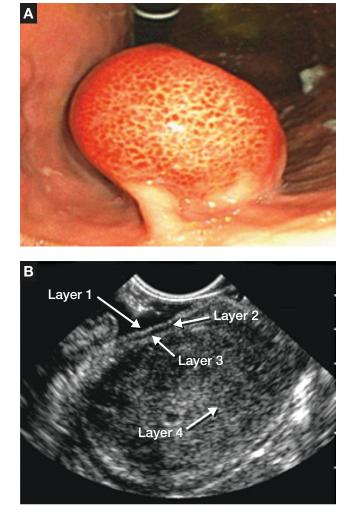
Pedunculated Gastric Gastrointestinal Stromal Tumor (GIST). A, Endoscopic image. B, Endoscopic ultrasonographic image. Endoscopic ultrasonography can demonstrate 5 wall layers, but only 4 layers are seen in this image. Layer 1 is hyperechoic (white) and is the superficial mucosal interface. Layer 2 is hypoechoic (black) and is deep mucosa. Layer 3 is hyperechoic and represents the submucosa. Layer 4 is the muscularis propria; it is hypoechoic (black) and is the layer of origin of most GISTs. (Courtesy of Michael J. Levy, MD, Gastroenterology and Hepatology, Mayo Clinic. Used with permission.)
